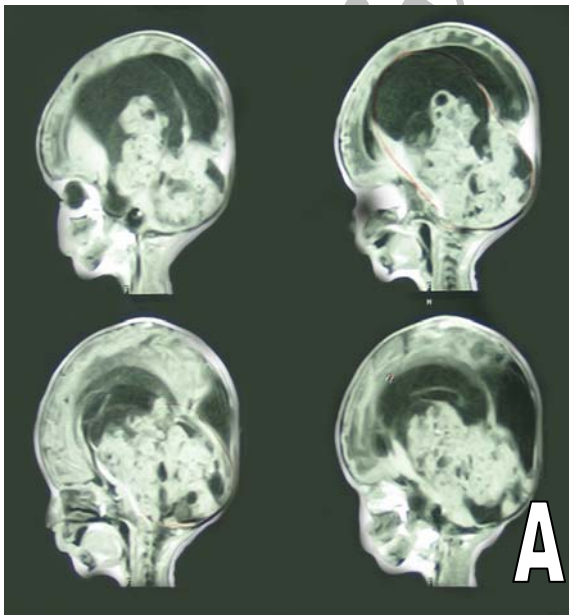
Congenital choroid plexus papilloma is displayed. T1-weighted magnetic resonance imaging with gadolinium enhancement shows a cauliflower-like mass filling the dilated third ventricle and its extension to both lateral ventricles with homogenous enhancement.
